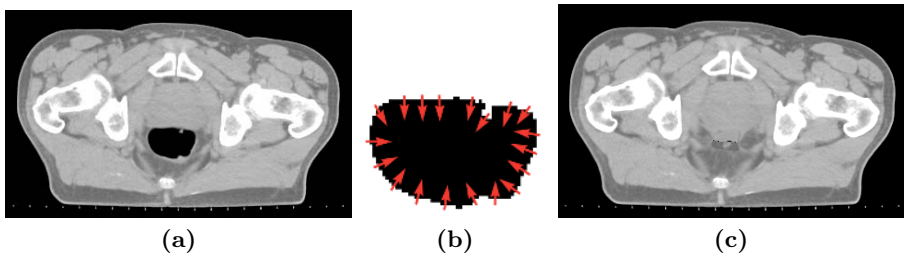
Gas Deflation Algorithm. (a) Axial slice CT image with large pocket of bowel gas. (b) Zoomed in on the gas pocket. The gas is segmented using simple thresholding. Gas is deflated by a flow induced by the gradient of the binary image. (c) The image after application of the deflation transformation.
